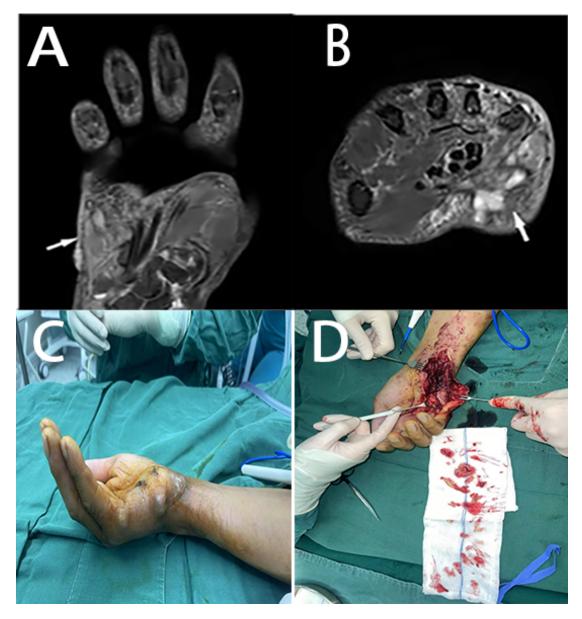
Preoperative MRI images and intraoperative pictures. (A,B) MRI images indicate edema of the ulnar soft tissue with multiple abnormal signal shadows and Hyperintensity of T2-weighted imaging (T2WI) signals (arrows). (C) External appearance of HPII with tendon contracture. (D) Surgical debridement of the right-hand palm.
